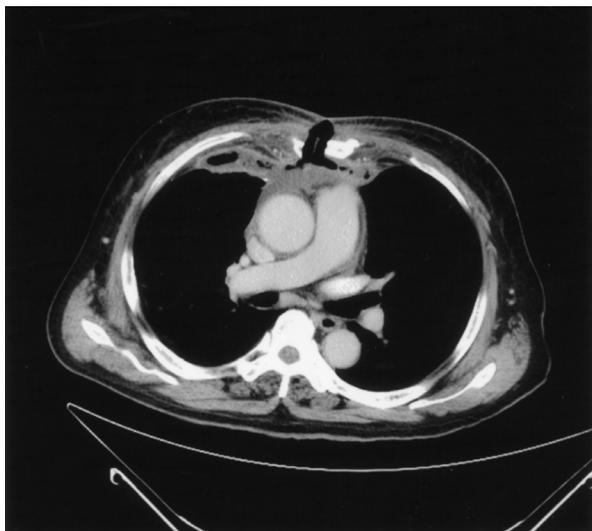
Chest CT scan showing anterior chest wall and mediastinal soft tissue infection with gas formation, abscess formation and pleural involvement.
